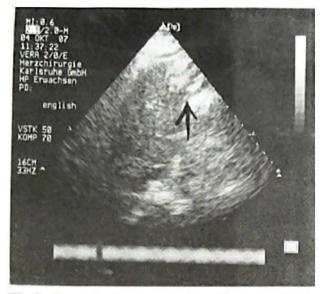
Stomach ultrasonography with arrow showing Thickened stomach cell wall in a patient with gastric GIST before Glivec
